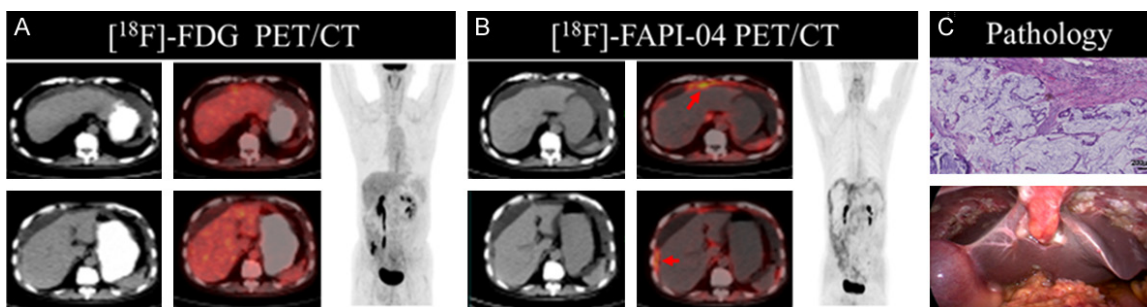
Detection results of a case of omental mucinous adenocarcinoma. A 65-year-old man was admitted with a hernia and elevated CA199 levels. During colonoscopy, access could not be achieved 20 cm from the anus. A CT scan of the whole abdomen was performed, showing a cystic solid occupancy in the appendix area. Further evaluation with [¹⁸F]-FDG PET/CT and [¹⁸F]-FAPI-04 PET/CT was performed before treatment. A. FDG: Wall peritoneum, no abnormal radioactive distribution. B. FAPI: Wall peritoneal thickening, showing abnormal radioactive concentration, SUVmax: 4.3. C. Surgical pathology shows mucinous adenocarcinoma of the greater omentum, Scale bar, 200 μm.
